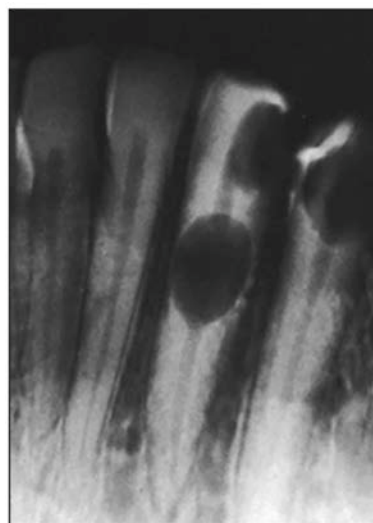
Periapical radiograph demonstrating ballooning of the pulp canal in tooth #22.
